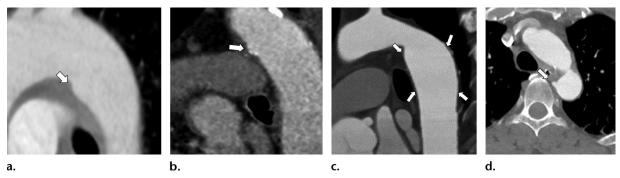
Anatomic mimics of MAI. (a, b) Sagittal multidetector CT images show ductus diverticulum without calcifications (arrow in a) and with small wall calcifications (arrow in b) with typical smooth convexity and congruity with the native aortic wall. (c) Sagittal multidetector CT image shows aortic spindle (arrows) with typical smooth and symmetric increase in the caliber of the aorta just below the isthmus. (d) Axial multidetector CT image depicts vascular infundibulum with its typical conical shape and a vessel emanating from its apex (arrow).
